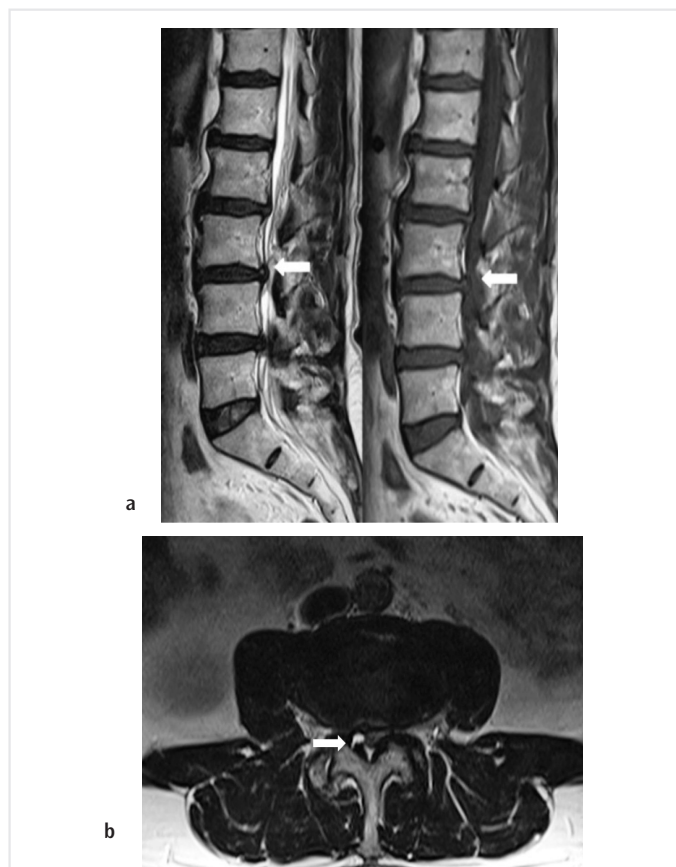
a) Sagittal T1-weighted imaging (T1WI) and T2-WI); b) axial magnetic resonance imaging showing cystic lesion (arrows) in the thickened ligamentum flavum at the L3-L4 intervertebral level, which is hypointense on T1WI and hyperintense on T2W images
